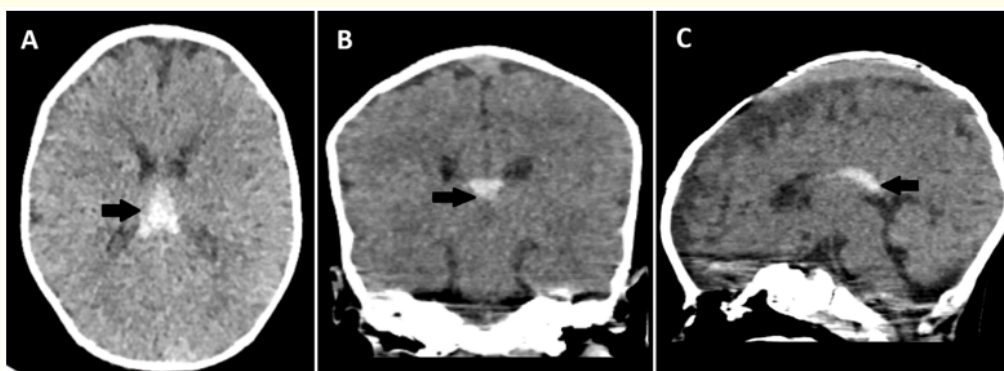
Isolated traumatic corpus callosum hematoma on non-contrast brain CT.
